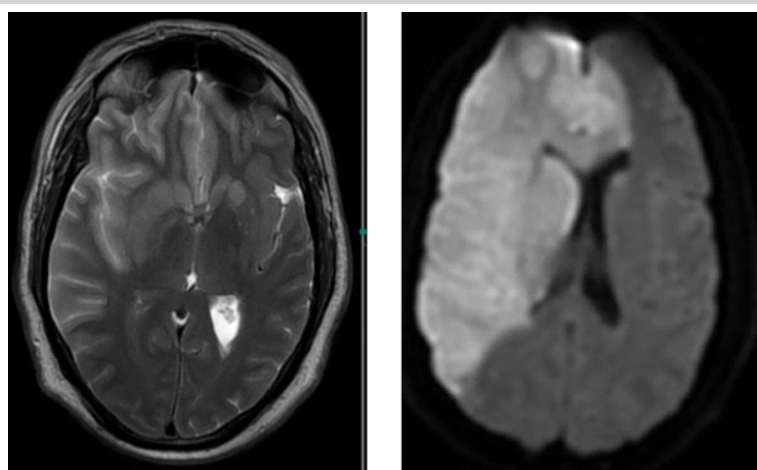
Magnetic resonance imaging of the brain suggestive of large acute infarcts in the right cerebral hemisphere.
